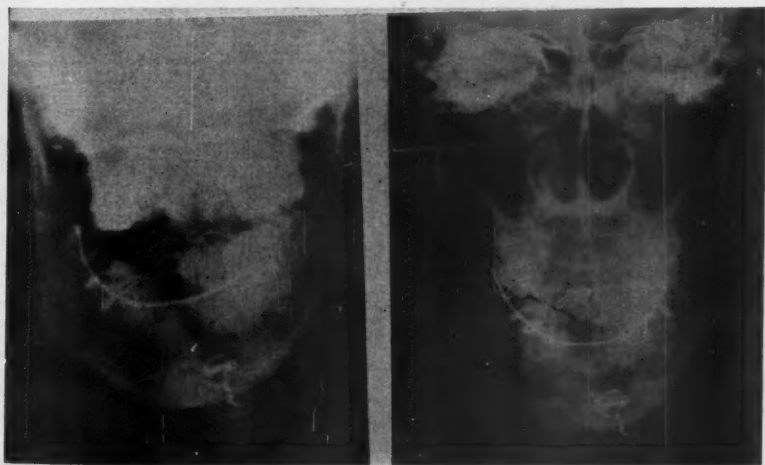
Case 2. The roentgenogram on the left shows the position of the mandibular fractures both at the symphysis and at the right angle after direct fixation of the former, and following application of a lower arch bar. On the right is a roentgenogram made 48 hours later showing excellent reduction and the teeth in good occlusion.
